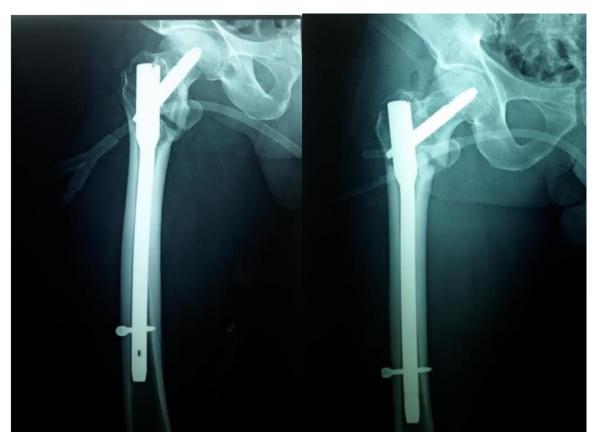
Immediate postoperative x-rays, showing the TAD= 18 mm
